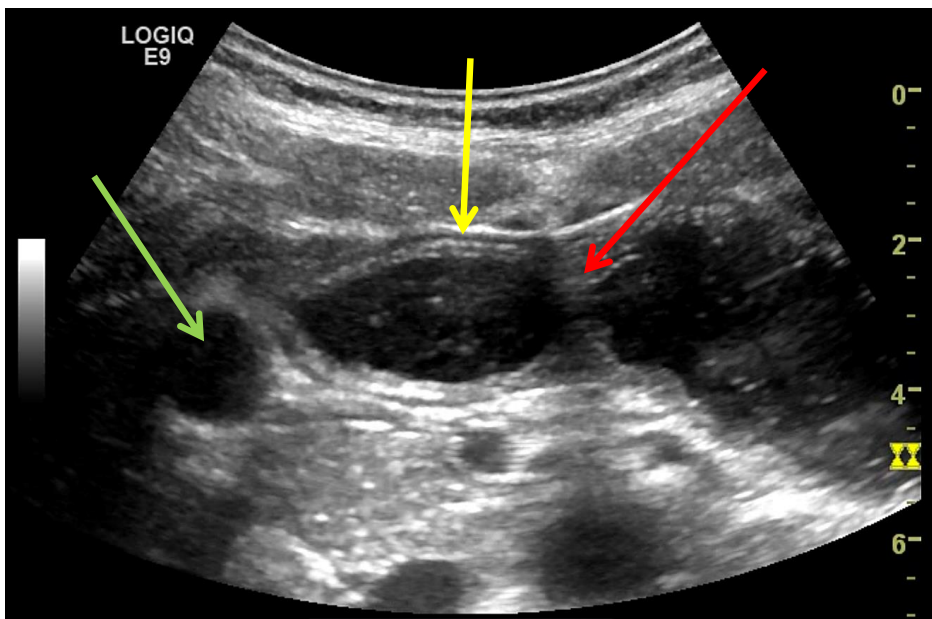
Transabdominal ultrasound, horizontal section of the antrum: In the middle of the picture, we can see a lumen occlusive contraction (marked by the red arrow) and the layers of the stomach wall (yellow arrow). The duodenal bulb is visible to the left (green arrow). Picture by Odd Helge Gilja, reprinted with permission.
